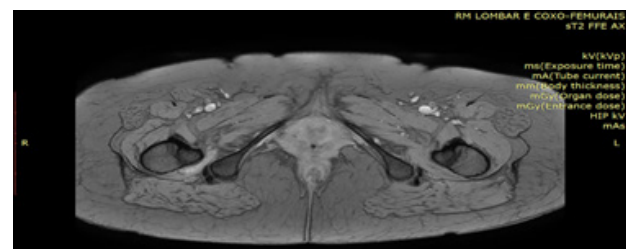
MRI of the hip joints identifies edema in the right quadratus femoris muscle.
